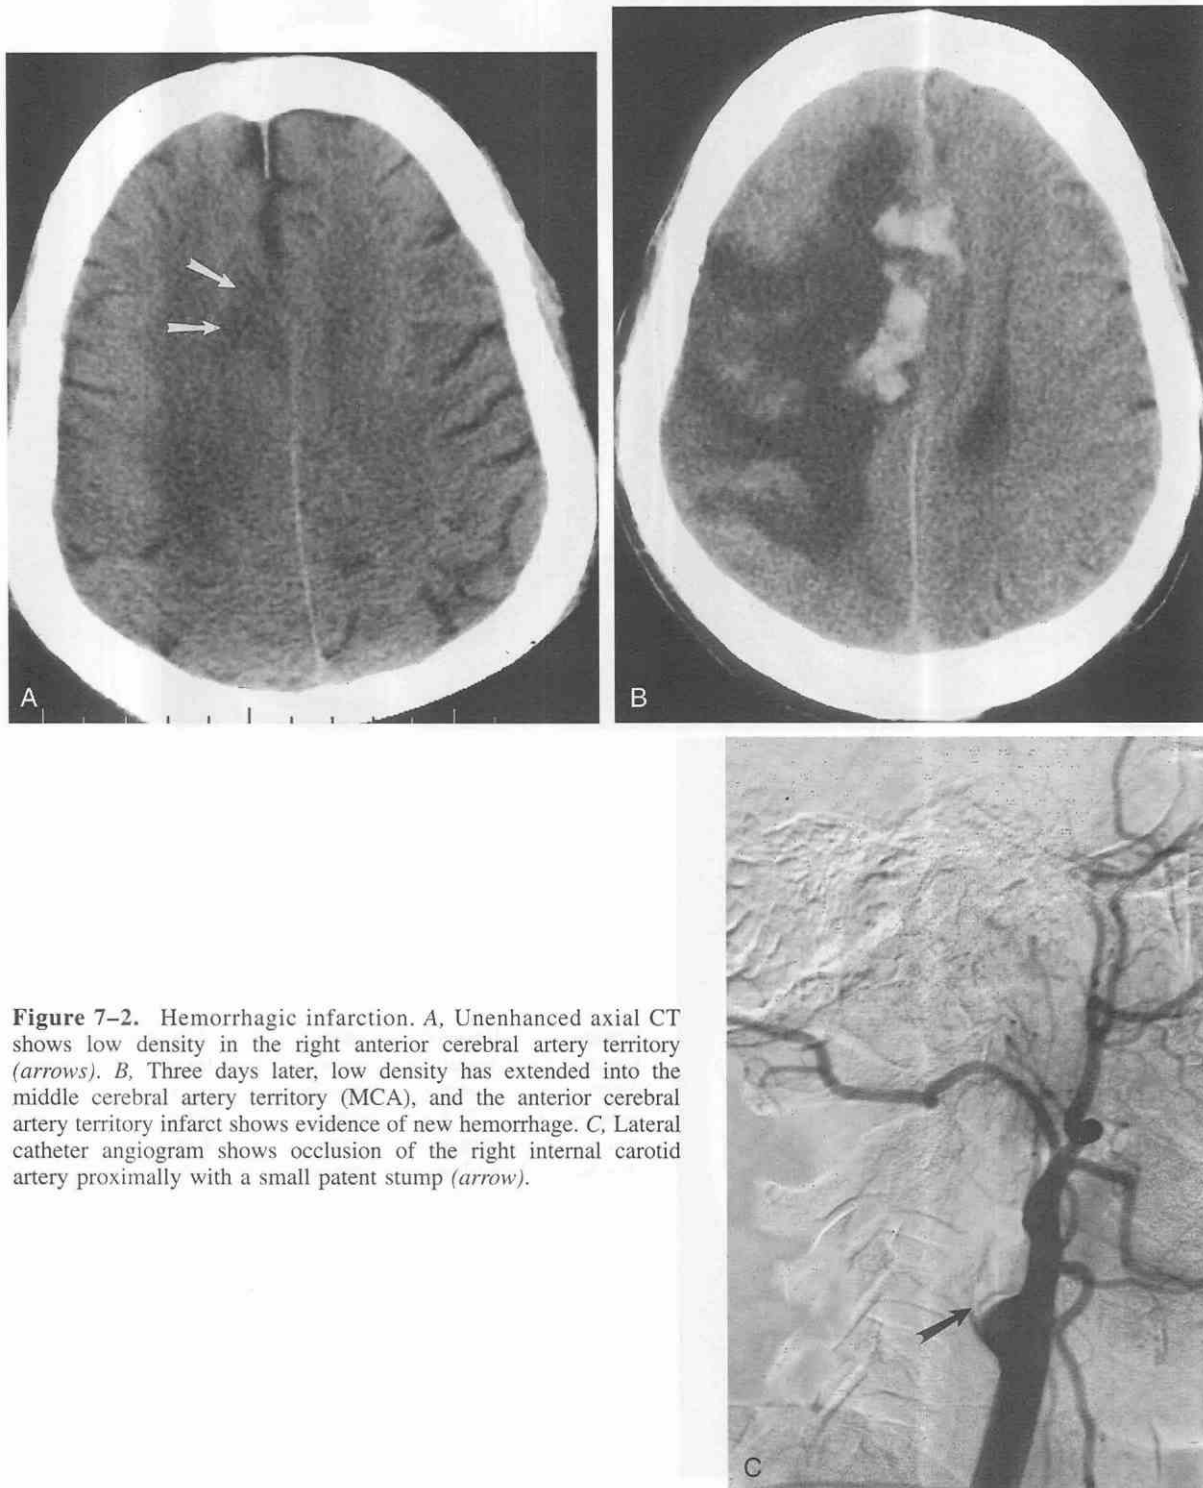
Hemorrhagic infarction. *A*, Unenhanced axial CT shows low density in the right anterior cerebral artery territory (*arrows*). *B*, Three days later, low density has extended into the middle cerebral artery territory (MCA), and the anterior cerebral artery territory infarct shows evidence of new hemorrhage. *C*, Lateral catheter angiogram shows occlusion of the right internal carotid artery proximally with a small patent stump (*arrow*).
